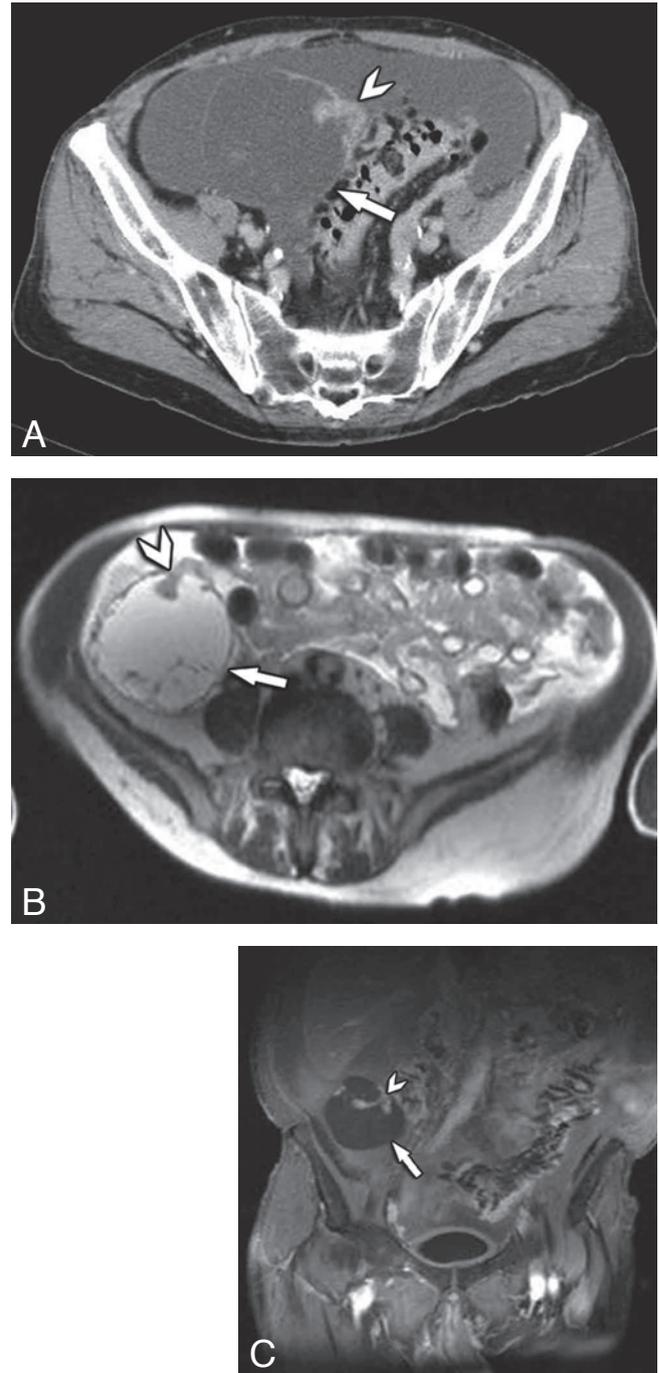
Axial CT scan (A), axial MR T2 HASTE (B) and coronal MR T1 GRE (C) with gadolinium from a 75-year-old man with a mucinous cystadenocarcinoma (white arrows) show internal septations, a papillary projection and irregular mural wall thickening (white arrowheads).
